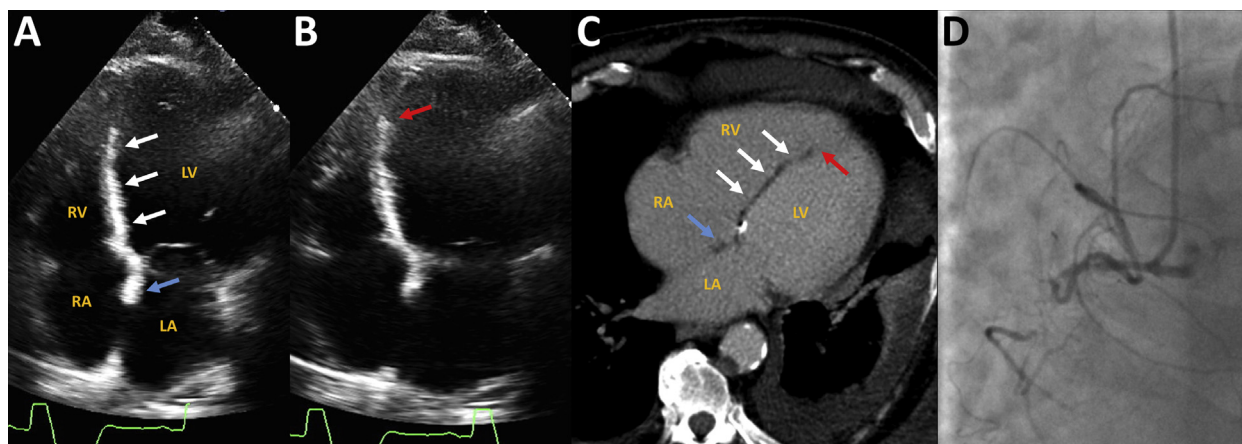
Transthoracic echocardiography in the four-chamber view at end-diastole (A) and end-systole (B) demonstrates a hyperechoic, akinetic, hyperechoic region in the basal to mid inferoseptum (*white arrows*). A sharp demarcation exists between the hyperechoic, akinetic basal to mid inferoseptal segments and the apical septum, which demonstrates normal wall motion (*red arrow*). The anterior aspect of the interatrial septum demonstrates similar echogenicity to the hyperechoic region of the inferoseptum (*blue arrow*). (C) Contrast-enhanced computed tomography shows a region of low density compatible with fat in the interventricular septum (*white arrows*) that correlates with the hyperechoic zone noted on echocardiography. Computed tomography also shows a clear delineation between the fat in the interventricular septum and the normally enhancing myocardium in the apical septum (*red arrow*), as well as lipomatous infiltration of the anterior interatrial septum (*blue arrow*). (D) Invasive coronary angiography reveals total occlusion of the proximal right coronary artery.
